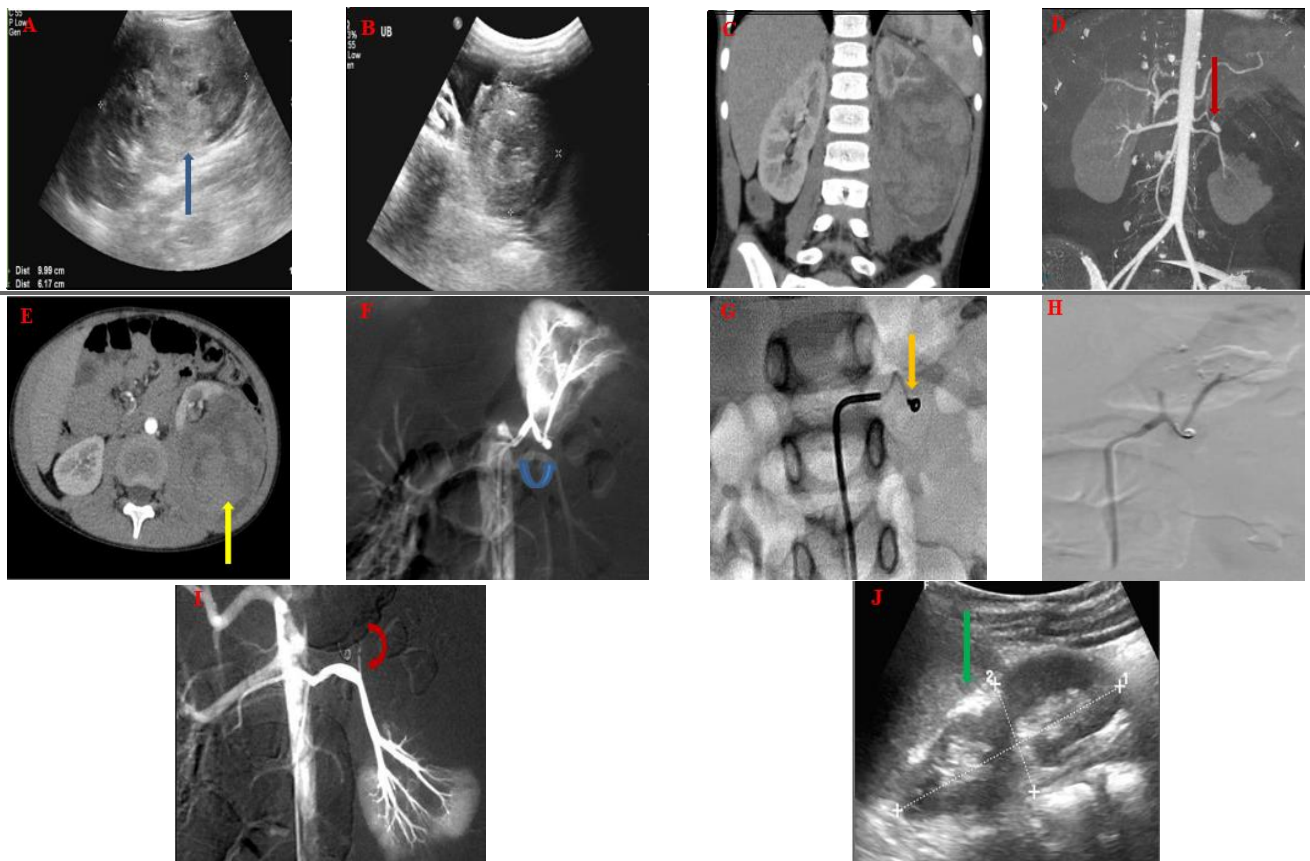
(A and B) abdominal ultrasound revealed enlarged left kidney with evidence of large heterogeneous lesion (10x6cm) at mid zone with no detected internal vascularity likely hematoma with preserved shape of upper and lower poles (blue arrow). Also, hyper echoic blood clot is seen in urinary bladder, CTU and CTA of renal vessels (C)coronal image, (D) coronal MIP image and (E) axial image revealed distorted left kidney with complete separation of the upper and lower part and double left renal arteries with aneurysm seen arising at the superior branch supplying upper part(red arrow) . In addition to presence of large perinephric and intra renal hematoma(yellow arrow) and evidence of contrast material inside the hematoma, (F) diagnostic selective left renal angiography revealed double left renal arteries then selective catheterization of upper branch was done, revealed small pseudo aneurysm from lower segmental branch (curved yellow arrow), (G) Coiling of aneurysm with microcoil by microcatheter under fluoroscopic control (orange arrow), (H and I) post-embolization control angiography revealed successful embolization with no further opacification with completer occlusion aneurysm(curved red) and (J)follow up by abdominal U/S scan 6 months after coiling
